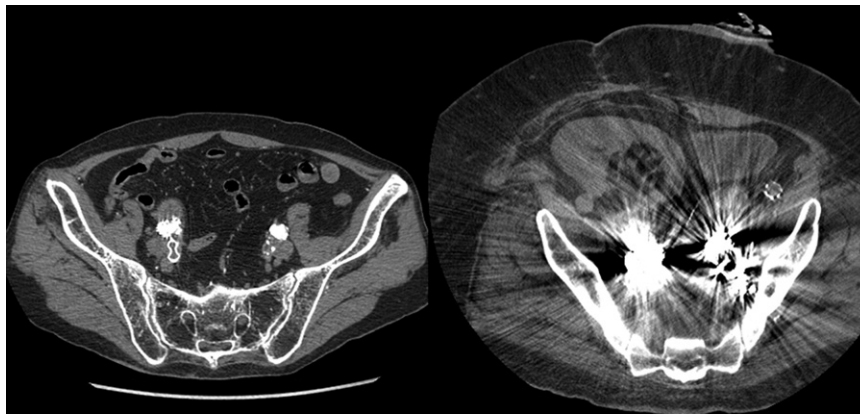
Right: CT scan of pelvic area containing coils in the hypogastric artery following EVAR. Note the massive artifact making difficult the identification of possible leaks in the area or other pelvic pathology. Left: Pelvic CT scan with a nitinol plug in the hypogastric artery. Note the lack of image artifact.
